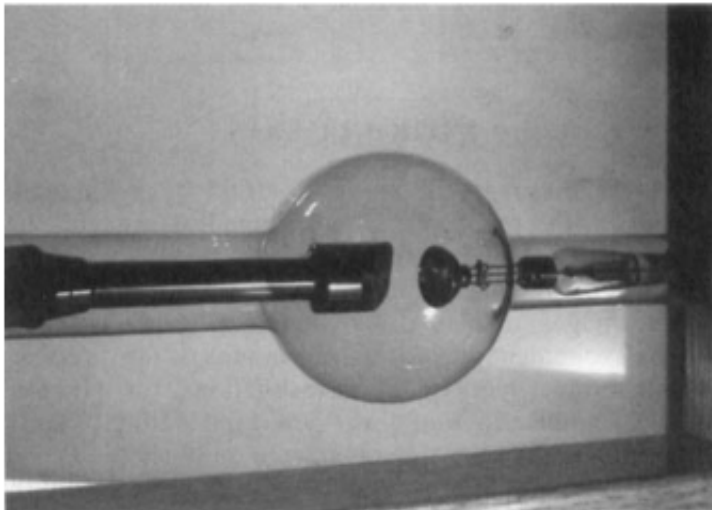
The Coolidge X-ray Tube [1].
